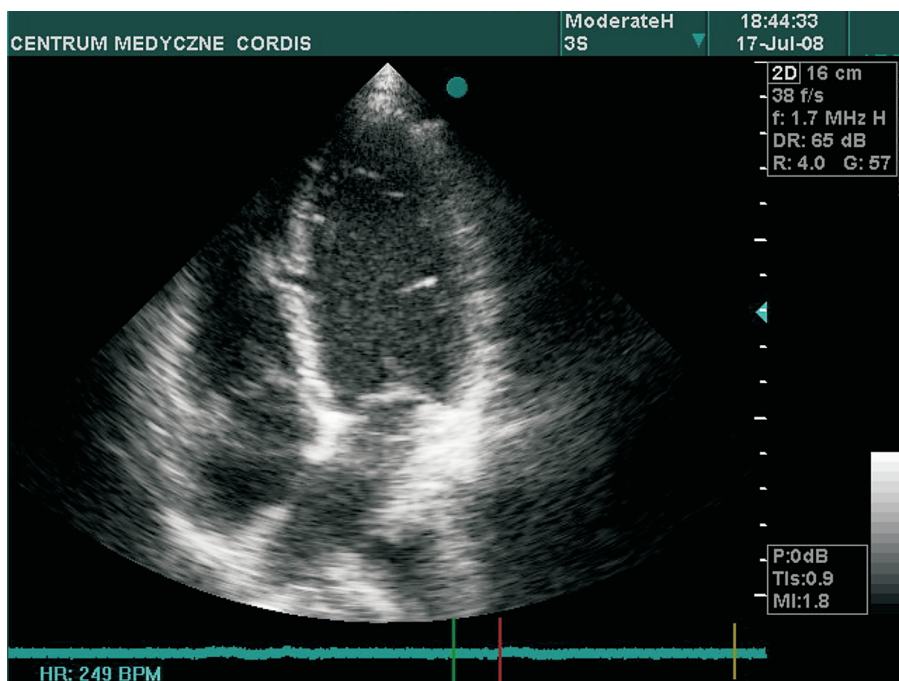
Echocardiography. Ventricular septal defect (VSD)
